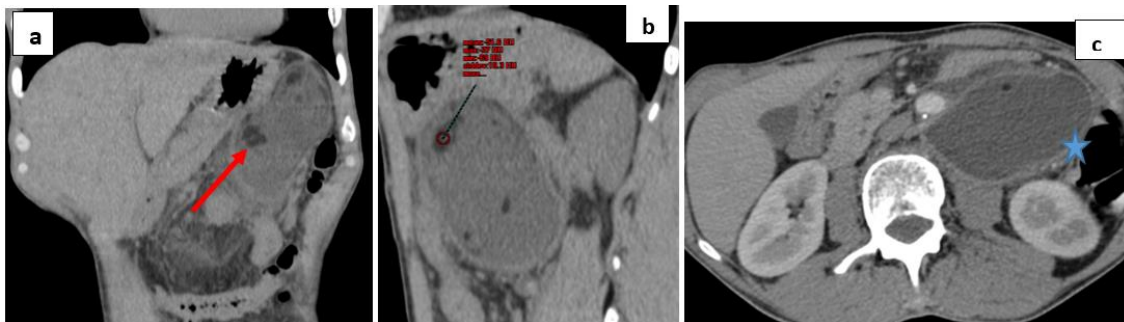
Abdominal CT scan without (a, b) and after iodinated contrast administration (c)
